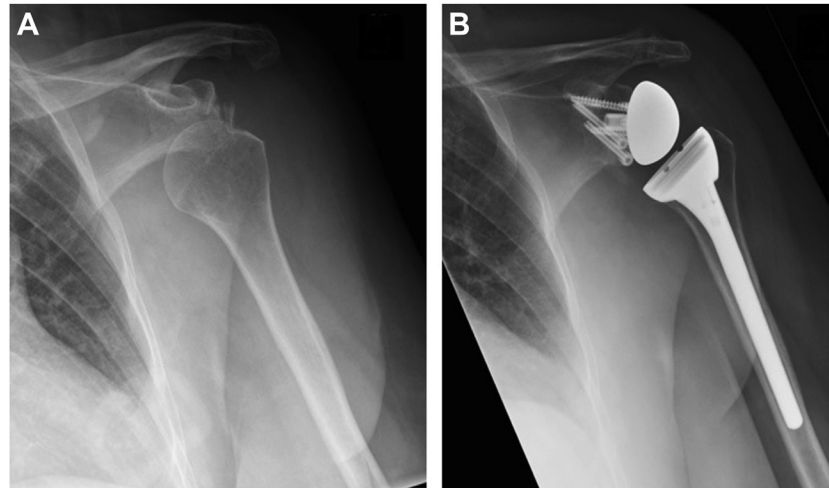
Preoperative (A) and postoperative (B) AP radiographs. AP, anterior to posterior.
